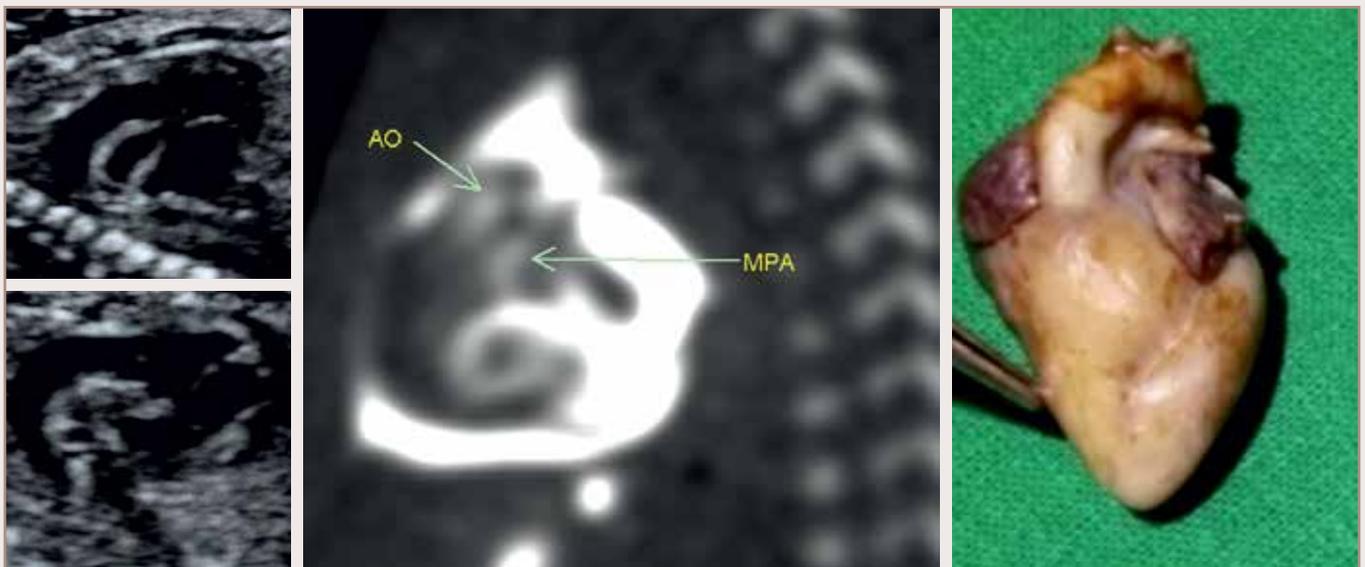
Antenatal sonography showing RV giving anterior aorta and posterior MPA abortus CT ventriculography shows accidental contrast injection into pericardial sac/ anterior aorta and posterior MPA/autopsy shows RV giving rise to anterior aorta and posterior main pulmonary artery-DORV with TGA
